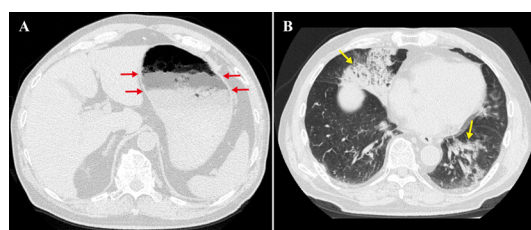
(A) Chest–abdomen–pelvis CT showing a double gastric fluid level (red arrows). (B) Chest–abdomen–pelvis CT showing consolidation in the right middle and left lower lobes (yellow arrows).
